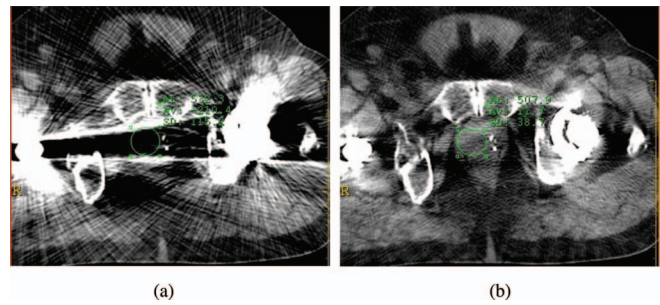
Improvement of CT Hounsfield number accuracy and noise for a patient with bilateral hip implants after metal artifact reduction. The image display window width is 400 HU, and window level is 800 HU. (a) Before O-MAR correction ROI CT number = -210.4 HU, $\sigma = 115.2$ HU. (b) After O-MAR correction ROI CT number = 11.7 HU, $\sigma = 38.7$ HU.
